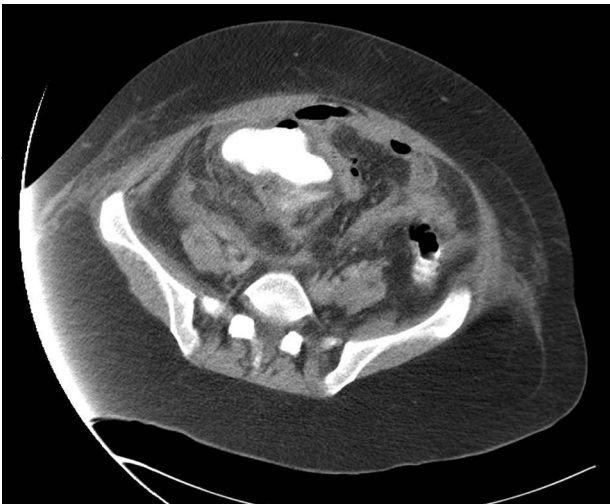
Severe peri-cecal inflammatory changes on CT scan.
